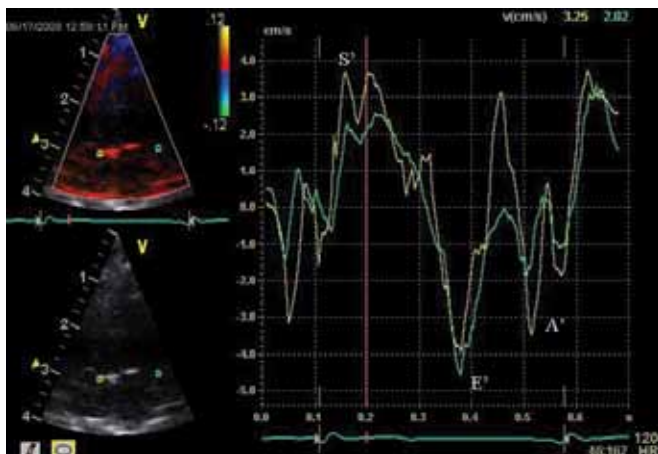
Apical 4-chamber view TV (upper left) obtained from a 1-mm sample area at the lateral wall (green dot) and septal wall (yellow dot) with overlapping Q-wave analysis of each wall (right). Peak systolic (S'), peak early diastolic (E'), and peak late diastolic (A') velocities are noted.
